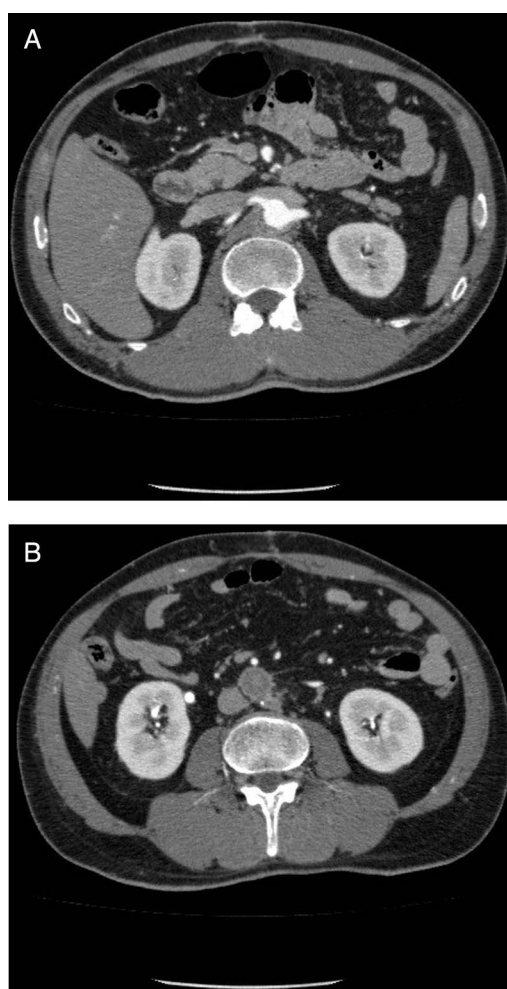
Contrast CT of the abdomen (A, level of renal arteries and B, infrarenal level).
